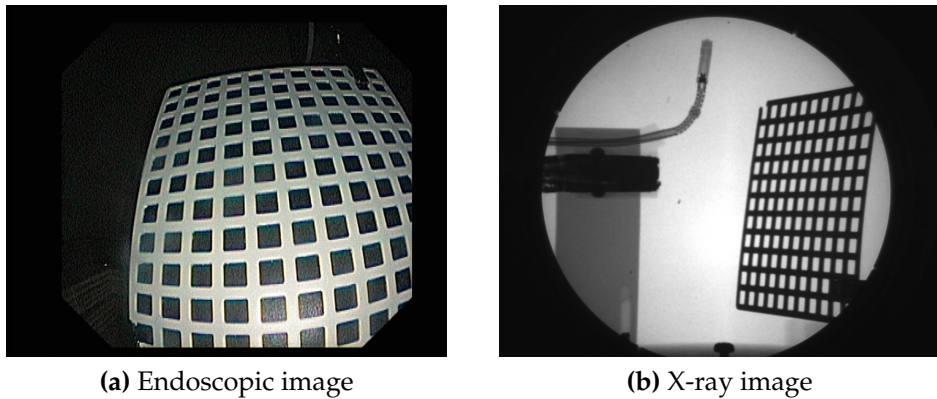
The stereo rig composed of (a) the endoscope camera and (b) the X-ray imager is calibrated by imaging a reference object using both image modalities. In (a), it can be observed that severe barrel distortion is present in the endoscopic images.
